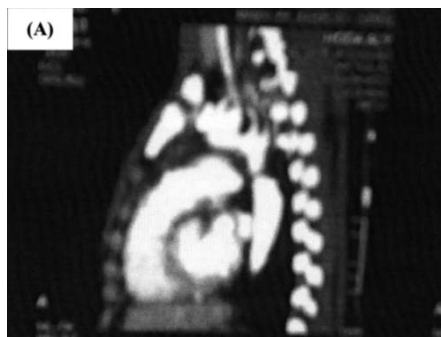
aortic coarctation (A) CT angiography (B) MRA of coarctation with extensive collaterals
